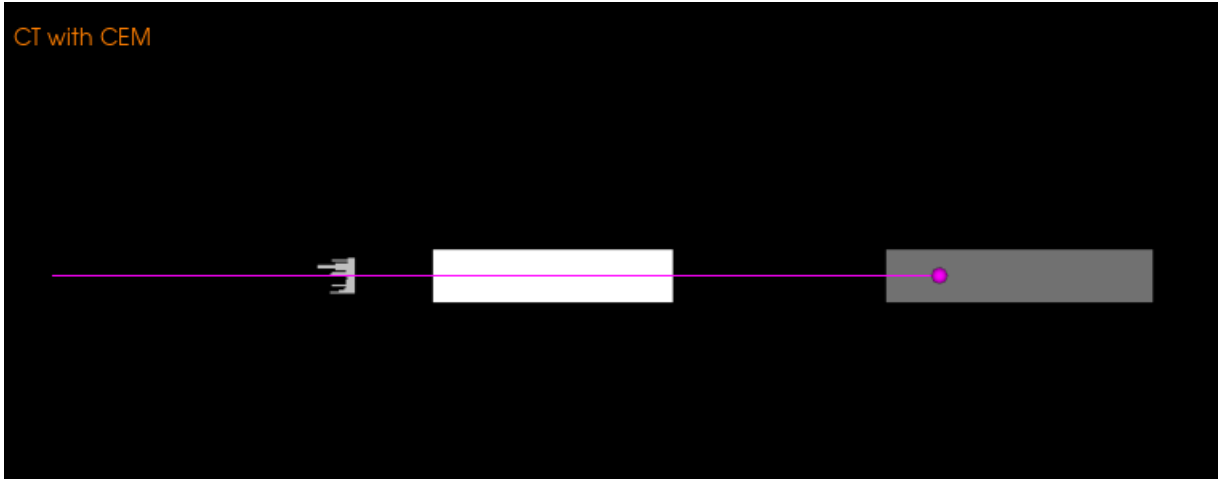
Example of a lateral view of a CT with CEM, range shifter, water tank, and distance (in purple) between the nozzle and the isocenter position
